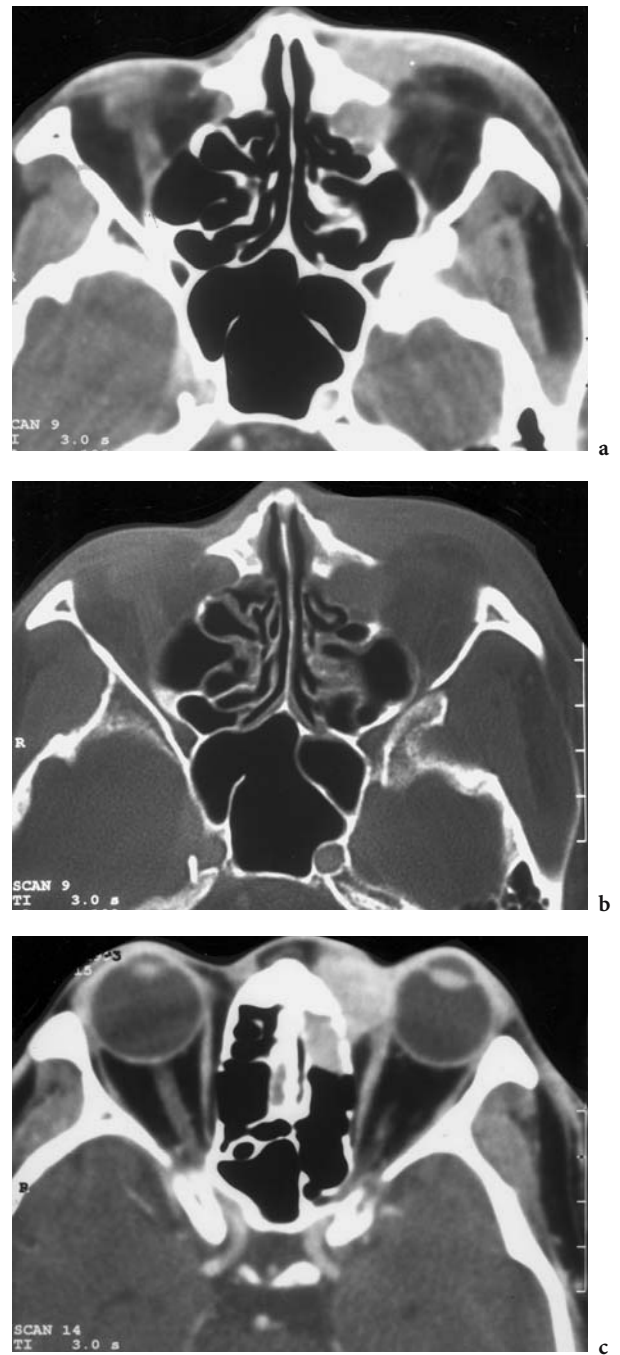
A 46-year-old man with chronic inflammation of the left lacrimal point. Diagnosis: lymphoepithelial tumor of the lacrimal duct. Axial contrast-enhanced CT: a View of the inferior orbit, where in addition to a subcutaneous, solid tumor of the medial inferior lid, widening of the left nasolacrimal canal, filled with solid tumor mass, is observed. b Corresponding bone window, demonstrating the difference in the diameter of the nasolacrimal canal and decalcification of the surrounding maxillary bone. c Axial view of the center of the orbit. The largest part of the tumor mass extends preseptally, compressing and dislocating the left globe; a definite differentiation of infiltration of the tendon of the left medial rectus muscle is not possible (not confirmed by surgery)
